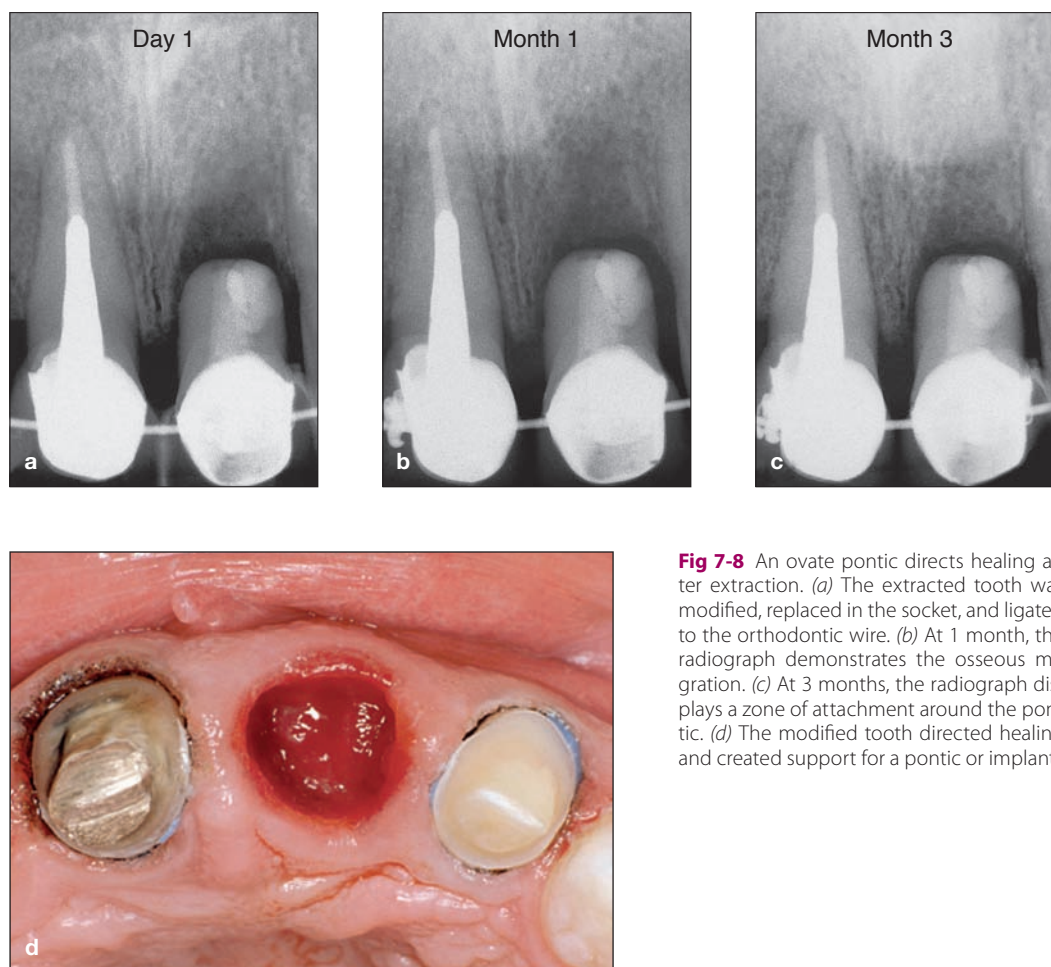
An ovate pontic directs healing after extraction. (a) The extracted tooth was modified, replaced in the socket, and ligated to the orthodontic wire. (b) At 1 month, the radiograph demonstrates the osseous migration. (c) At 3 months, the radiograph displays a zone of attachment around the pontic. (d) The modified tooth directed healing and created support for a pontic or implant.
